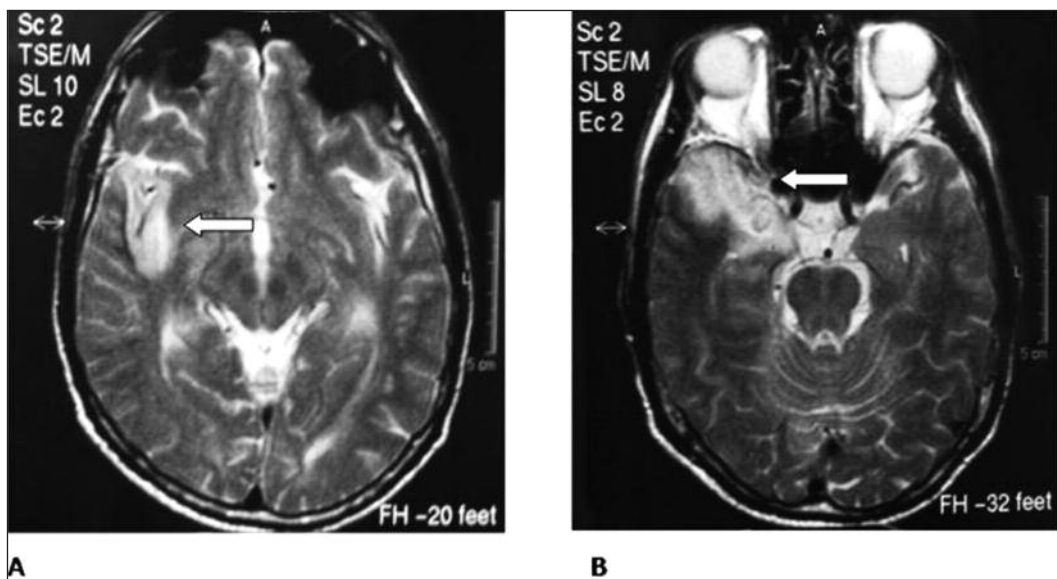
The arrows on T2- sagittal magnetic resonance image of the patient indicate the infarction in right insular cortex (A), and the infarction in right temporal lobe with cerebellar atrophy (B).
